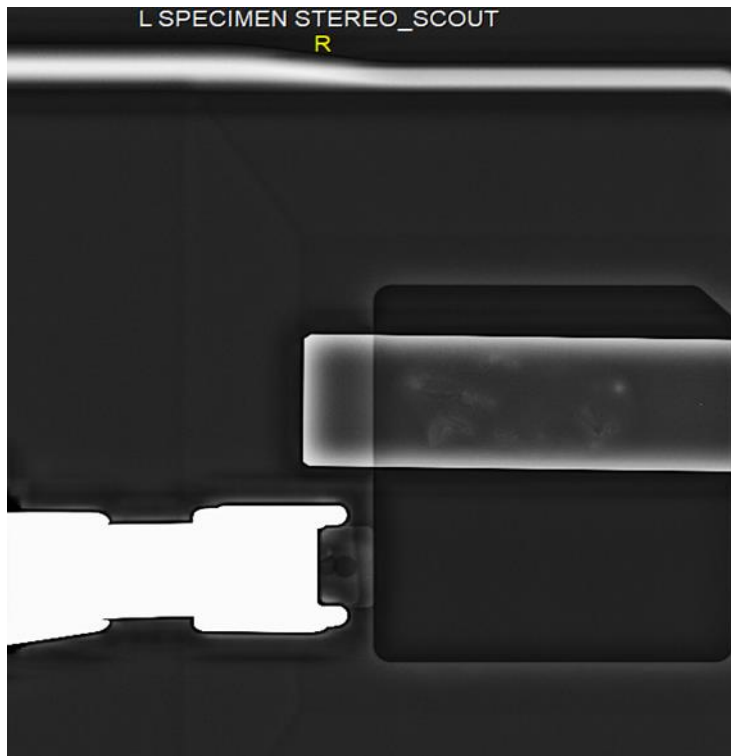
An x-ray of the tissue strands from female patient on a slide after the stereotactic biopsy was performed. (Imaging, Medical, 2020). Printed with permission.
